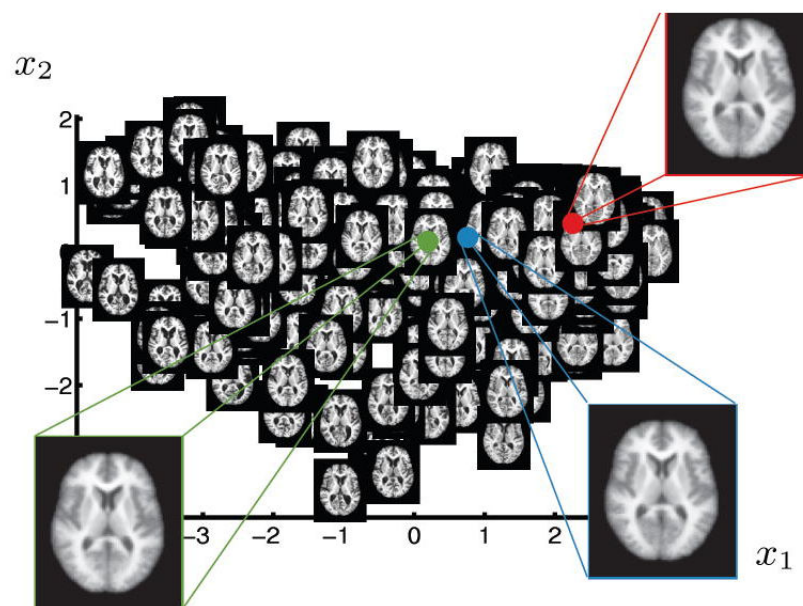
2D parametrization of OASIS brain MRI database obtained by a manifold subspace. This work raise the hypothesis that a low-dimensional, nonlinear model can effectively represent variability in brain anatomy such as ventricles size. For each brain image axial slice number 80 is visualized at the corresponding location on the 2D manifold. The insets show the mean (green), median (blue) and mode (red) of the learned manifold and the corresponding reconstructed images
